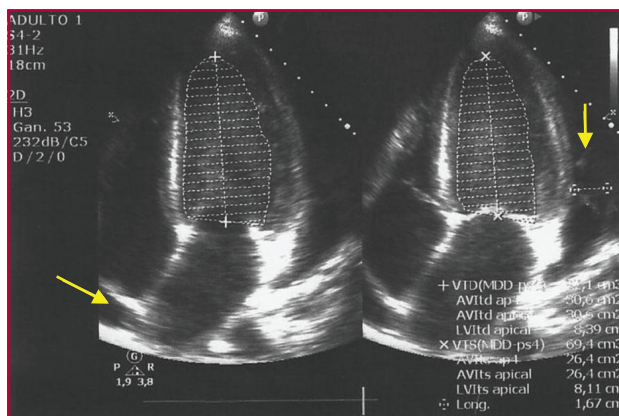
Transthoracic echocardiography. Four-chamber apical view. Pericardial effusion is observed, 17 mm laterally, with diastolic collapse of the right atrium.
